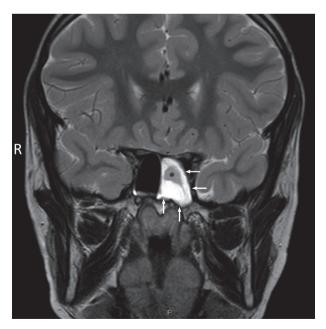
MRI coronal T2-weighed sequence showing the left sphenoid sinus covered by highly hyperintense edematous mucosa (arrows) with central hypointense signal suggestive of empyema (asterisk).
